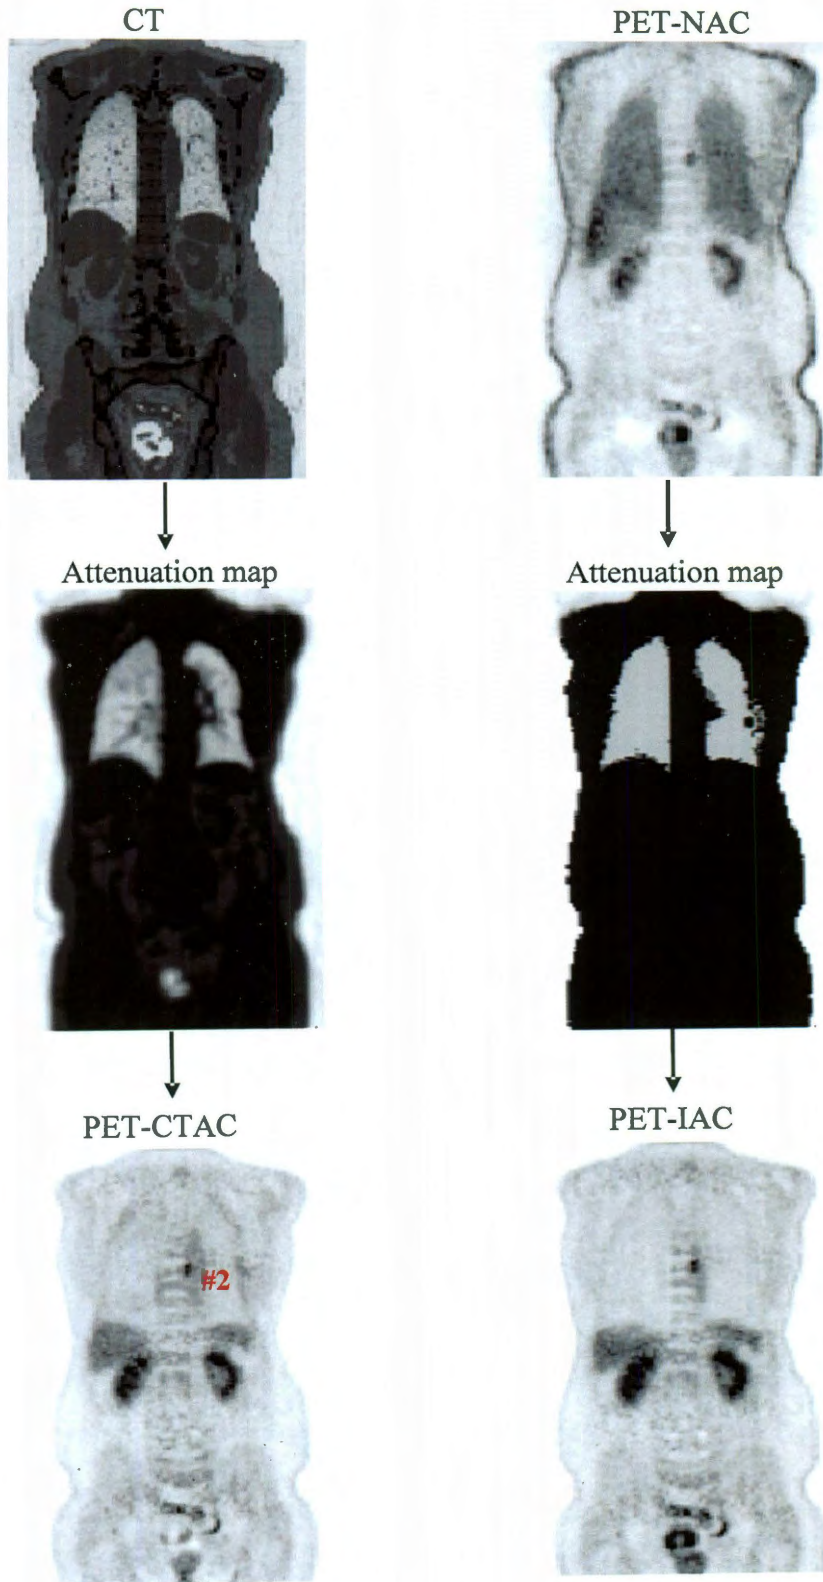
Comparison between PET-CTAC and PET-IAC of another patient.
